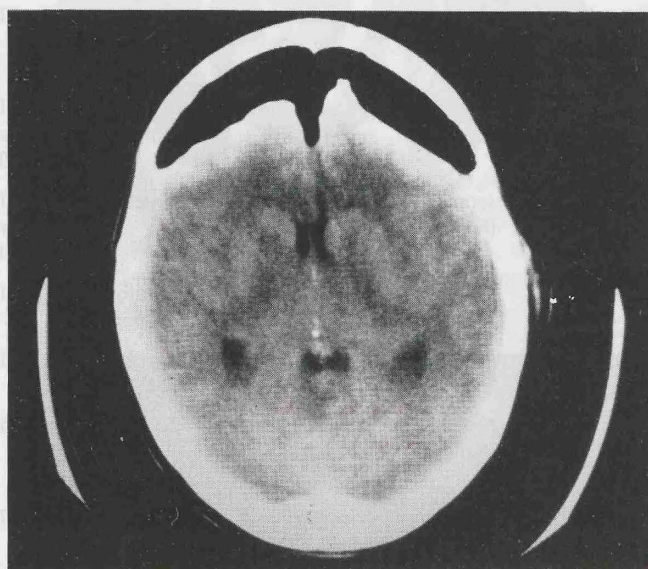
Axial CT-scan revealing air encephalocele in a patient associated with a CSF leak.
